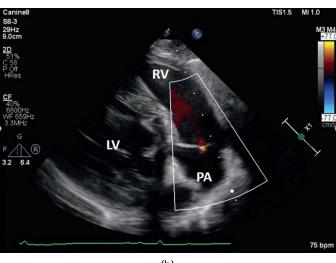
The right parasternal transverse view at the heart base of the pulmonary artery shows excellent color flow Doppler since flow is somewhat parallel to the direction of flow. (a) Early systole often shows normal aliased downward flow if the Nyquist limit is exceeded. (b) Late systole typically shows non-aliased blue colors as blood flow decelerates. (c) There is often trace to mild pulmonary insufficiency (arrow) during diastole in normal hearts. This insufficiency is always red and typically has minimal if any aliasing.
